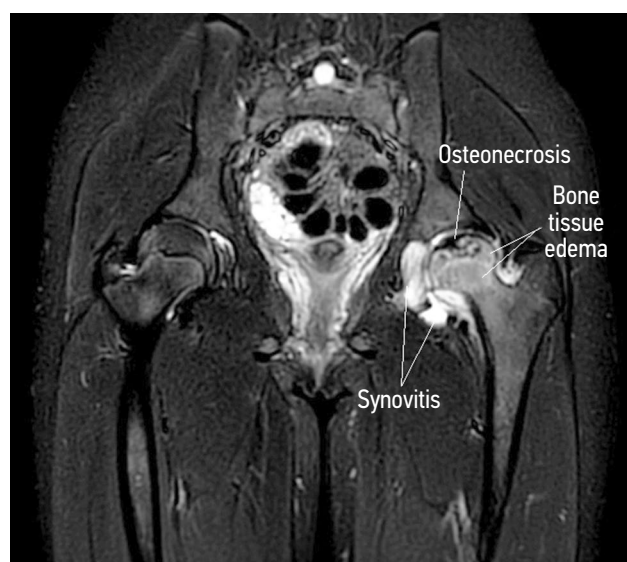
Magnetic resonance imaging: stage II osteochondropathy of the left femoral head with signs of osteoarthritis. The short-tau inversion recovery mode revealed an extensive destruction zone in the femoral head, reactive trabecular edema in the head and neck, and signs of chronic synovitis
